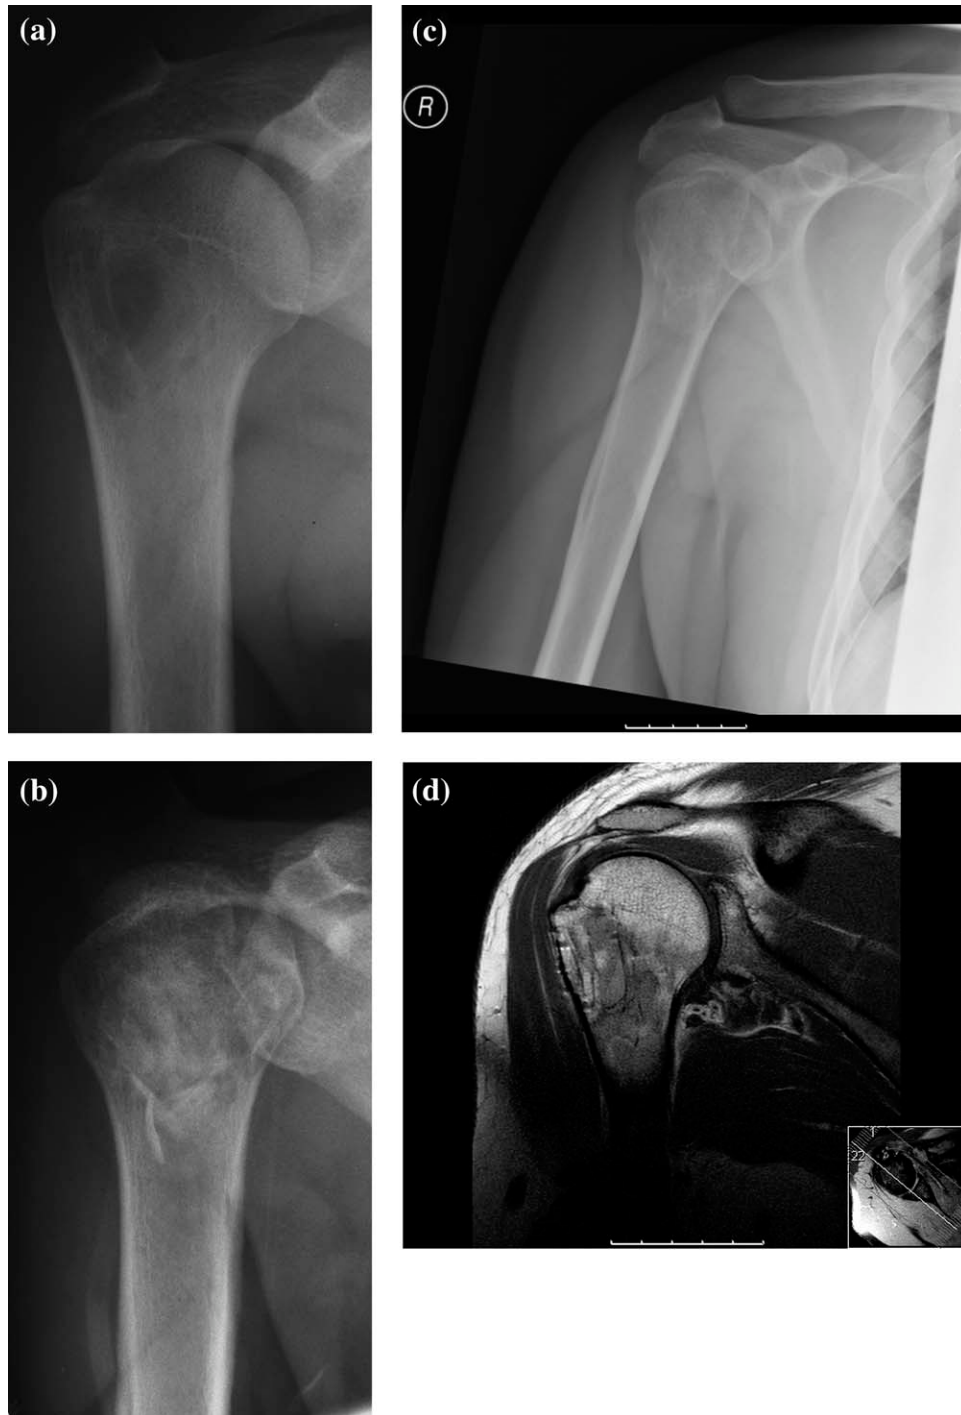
A simple bone cyst in the proximal humerus treated with AB, (a) preoperative X-ray, (b) postoperative X-ray showing cavity filled with AB, (c) long-term follow-up X-ray showing small sclerosis in the treated cavity, (d) long-term follow-up coronal T1 MRI of the treated cavity showing sclerosis and remnants of AB
